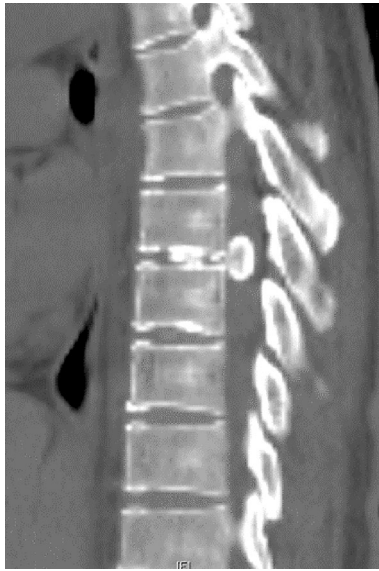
Sagittal CT demonstrating TDM caused by calcific discitis with herniation (CDH): CT demonstrated calcification of the nucleus pulposus in the intervertebral space along with calcification of the intervertebral disk protruding into the thoracic canal
